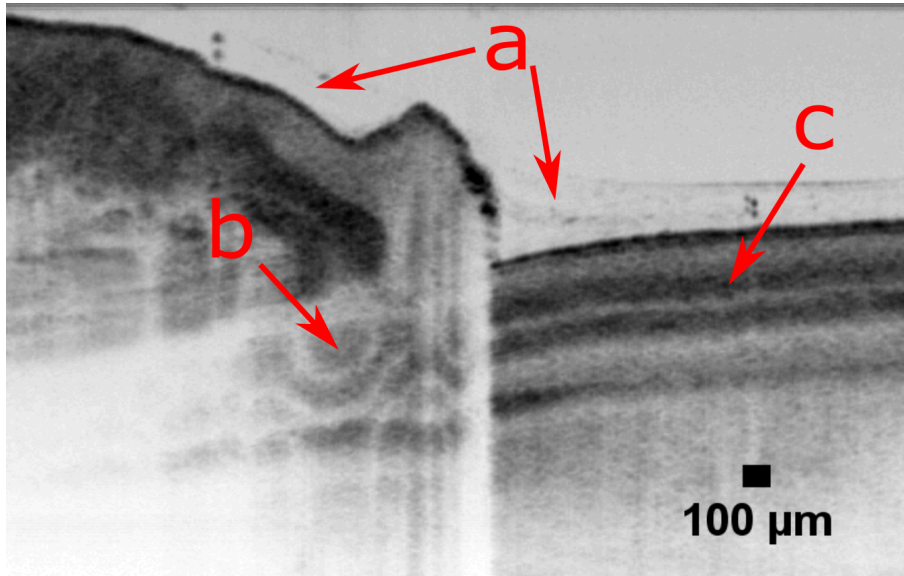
Structural image of the nailfold, treated with ultrasound gel applied to the surface, average of 250 B-scans. Arrows at a) mark the layer of ultrasound gel. The arrows at b) and c) mark ring and stripe artifacts that arise because of the birefringent properties of the nail.
